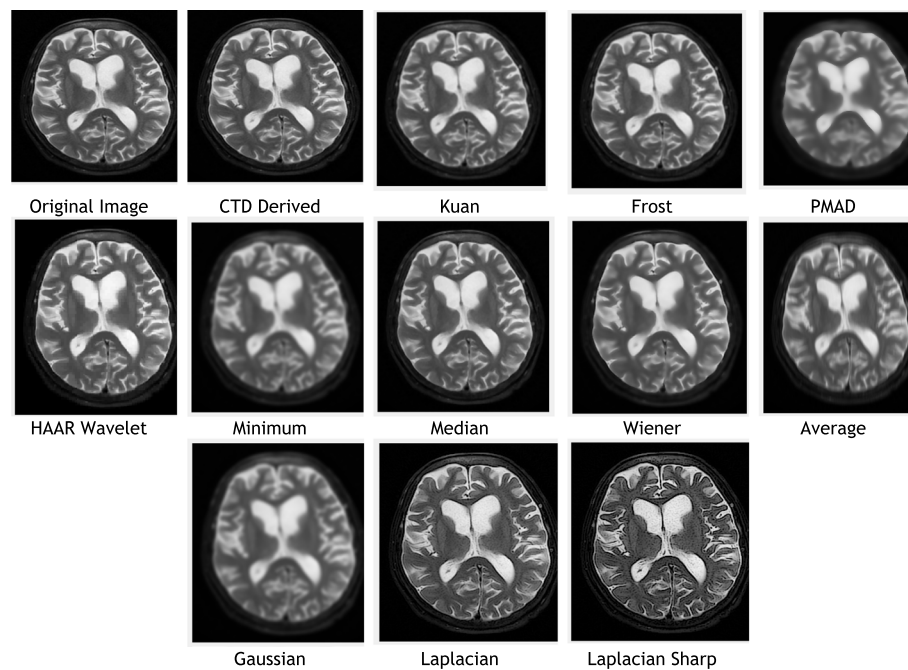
Original and denoised images of MRI MCA PROP T2
